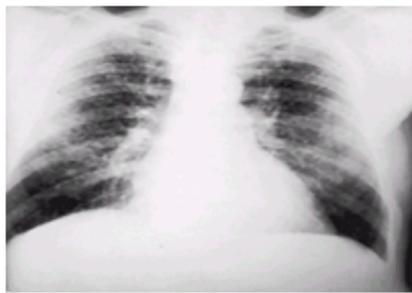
Radiograph of a subject with category 2/2, *q/q* simple CWP.
